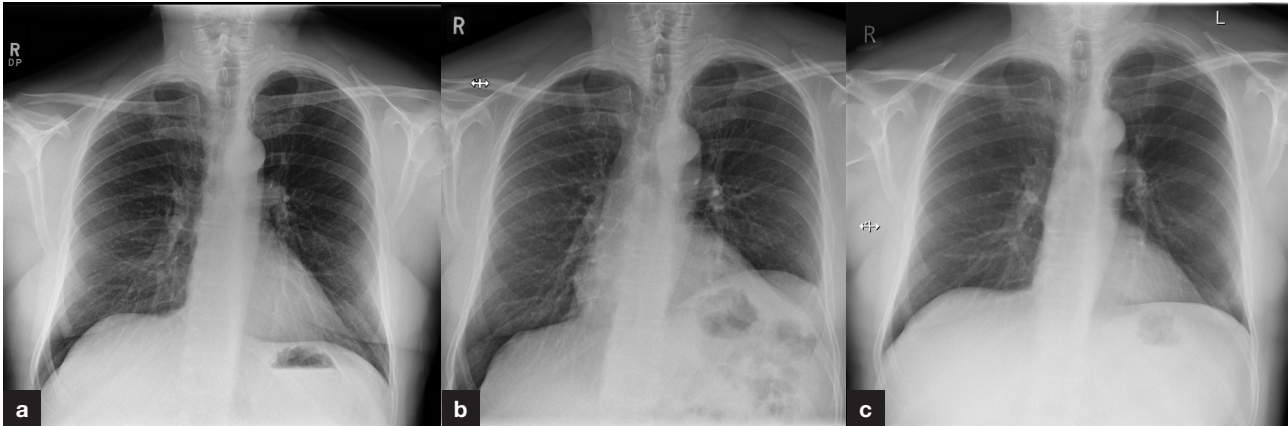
a. Chest X-ray on initial presentation. b. Chest X-ray showing raised left hemidiaphragm 6 months later. c. Chest X-ray with recovery of left hemidiaphragm 12 months after initial presentation.
